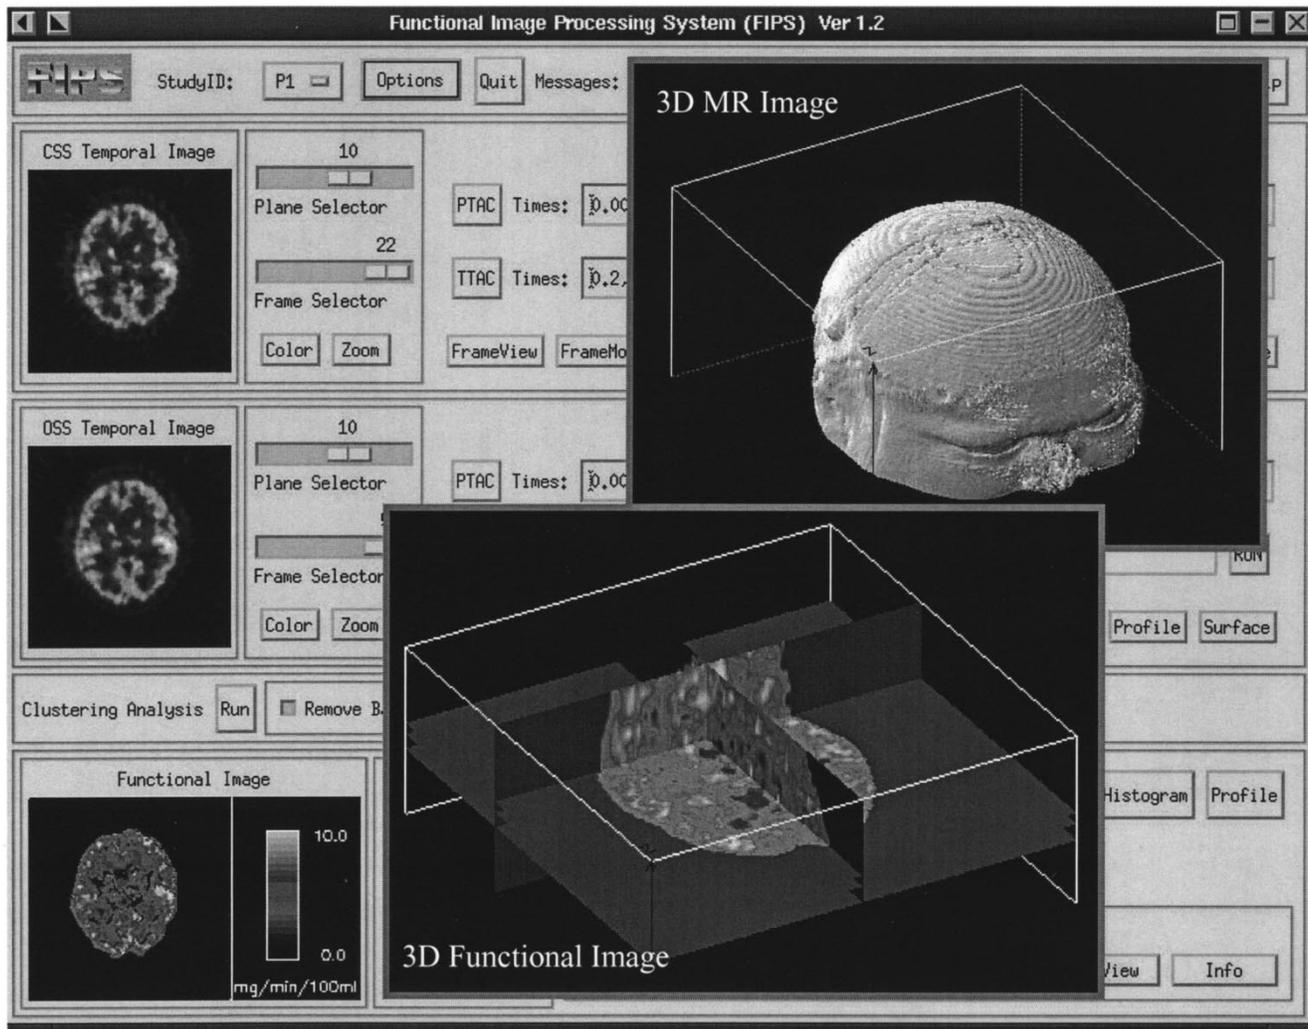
The output of a 3-D MRI volume image and a 3-D parametric image of cerebral metabolic rates of glucose generated by FIPS using the GLLS algorithm.
